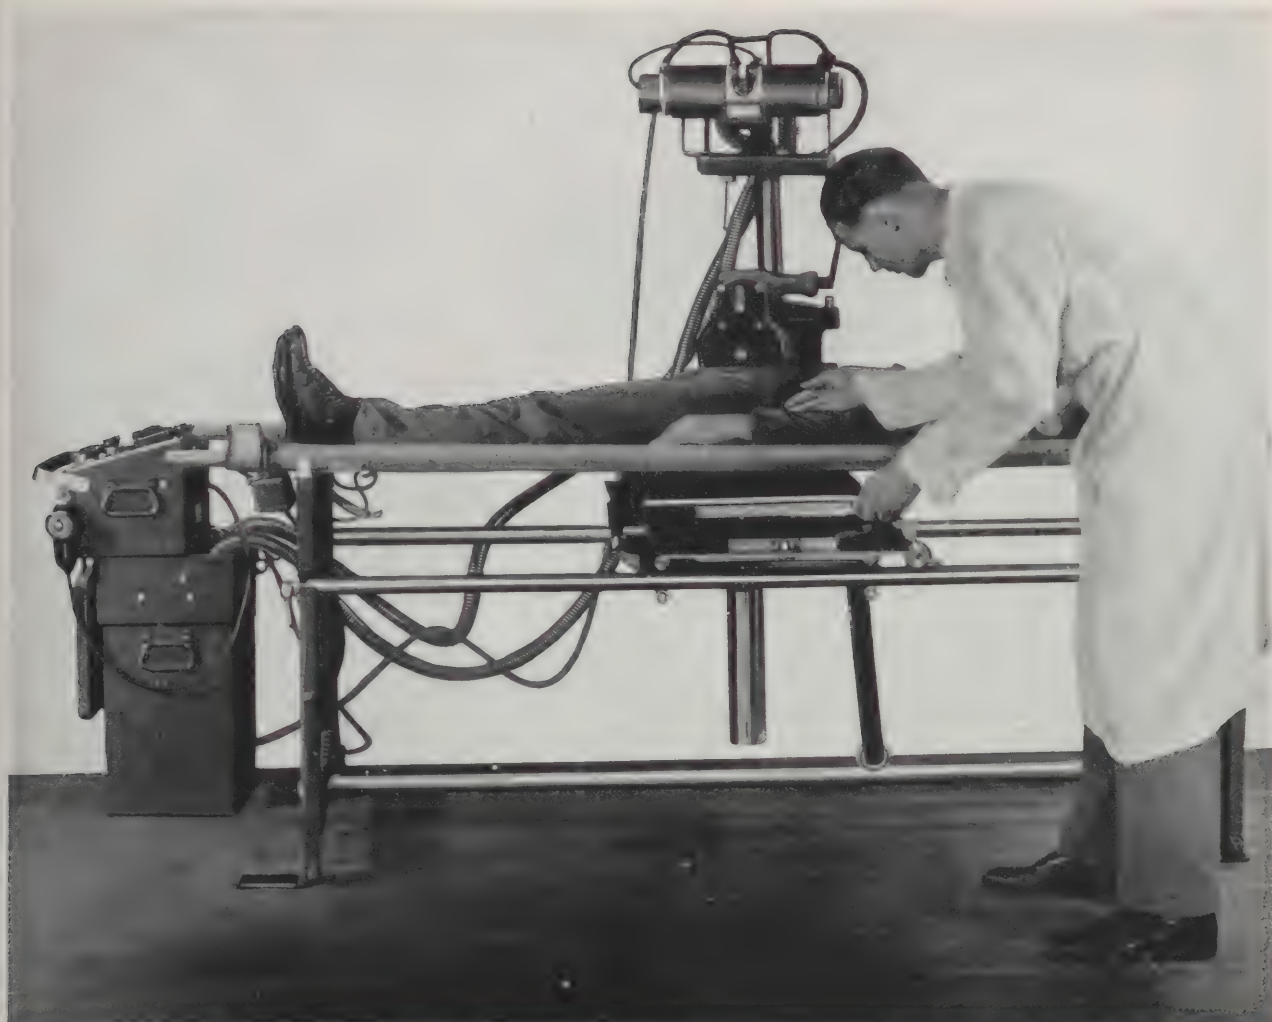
Item 96085 assembled with Item 96145 and Item 96070 for routine roentgenography.
